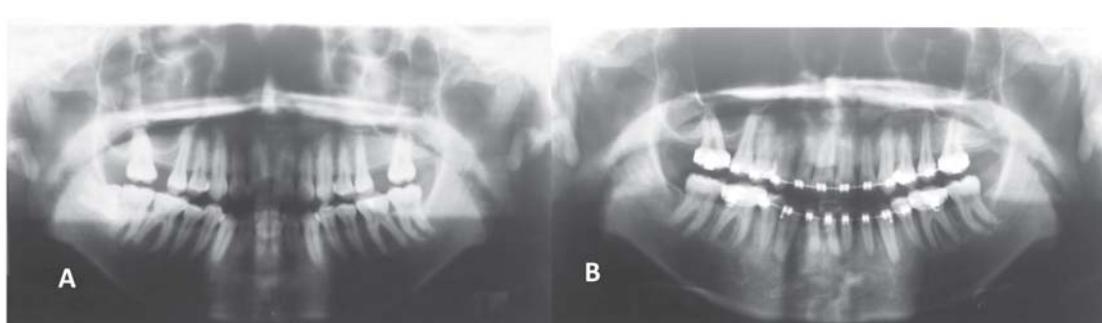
Initial radiographic image, showing the more vertical extension of maxillary sinus in right molar area (A). Radiographic image after space closure by orthodontic tooth movement, note the higher degree of tipping on the right compare to the left (B).
